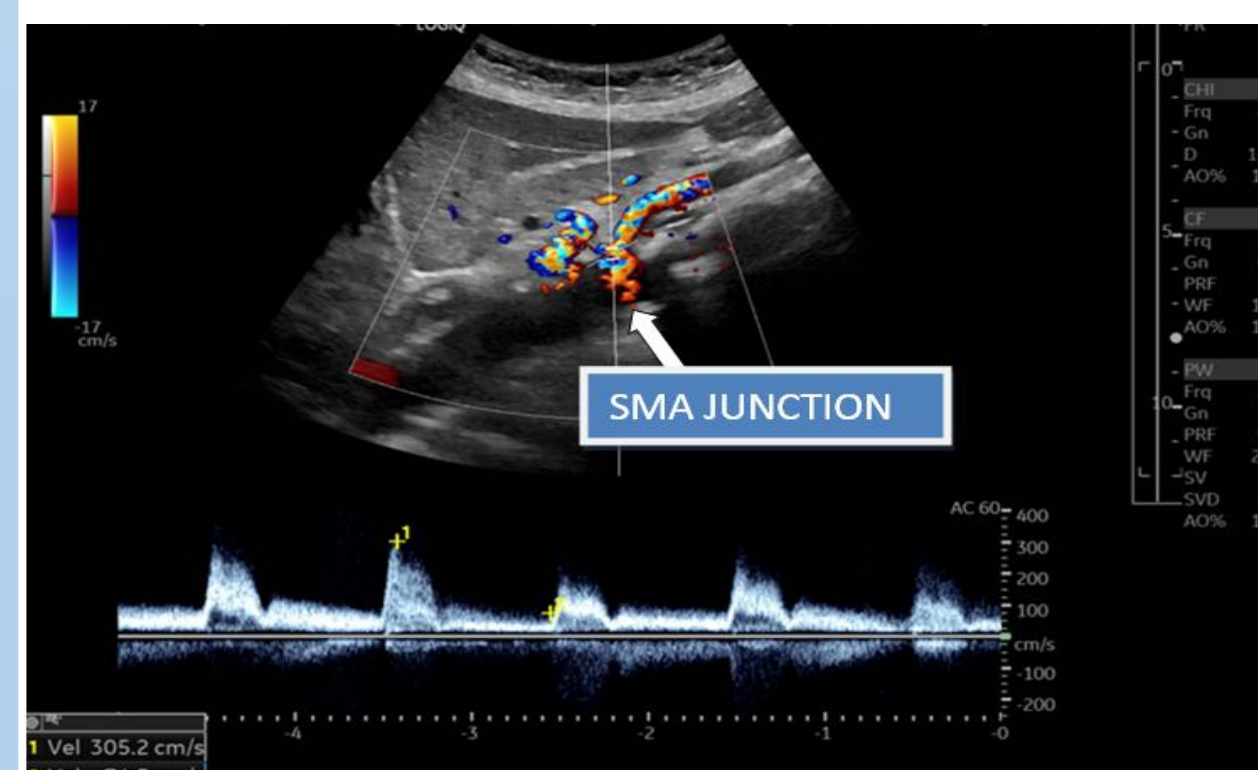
Spectral Doppler of the SMA indicating a peak systolic velocity of 305 cm/s.
